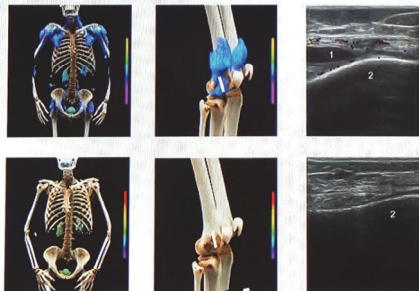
Cinematic rendering reformatted upper body FAPI-PET-CT scans (done in patient 2) at baseline (top) and follow up (bottom) showing a significant reduction in (left) muscle and (middle) joint fibroblast activity (blue). (right) Correlating knee ultrasound showing resolution of edema (1).
